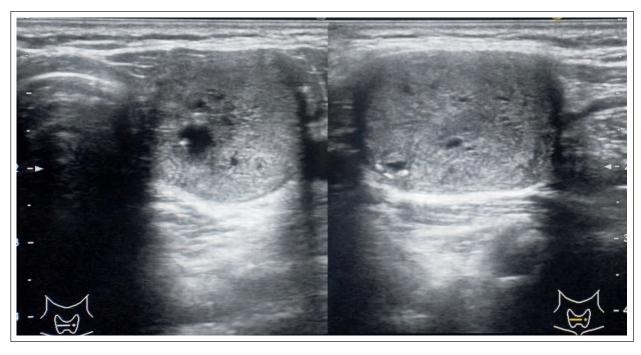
Ultrasound image of a thyroid nodule with suspicious features, due to post-radioactive iodine ablation changes; displaying a solid nodule, heterogeneous echotexture, and mixed calcifications, commonly seen in post-treatment tissue alterations.
